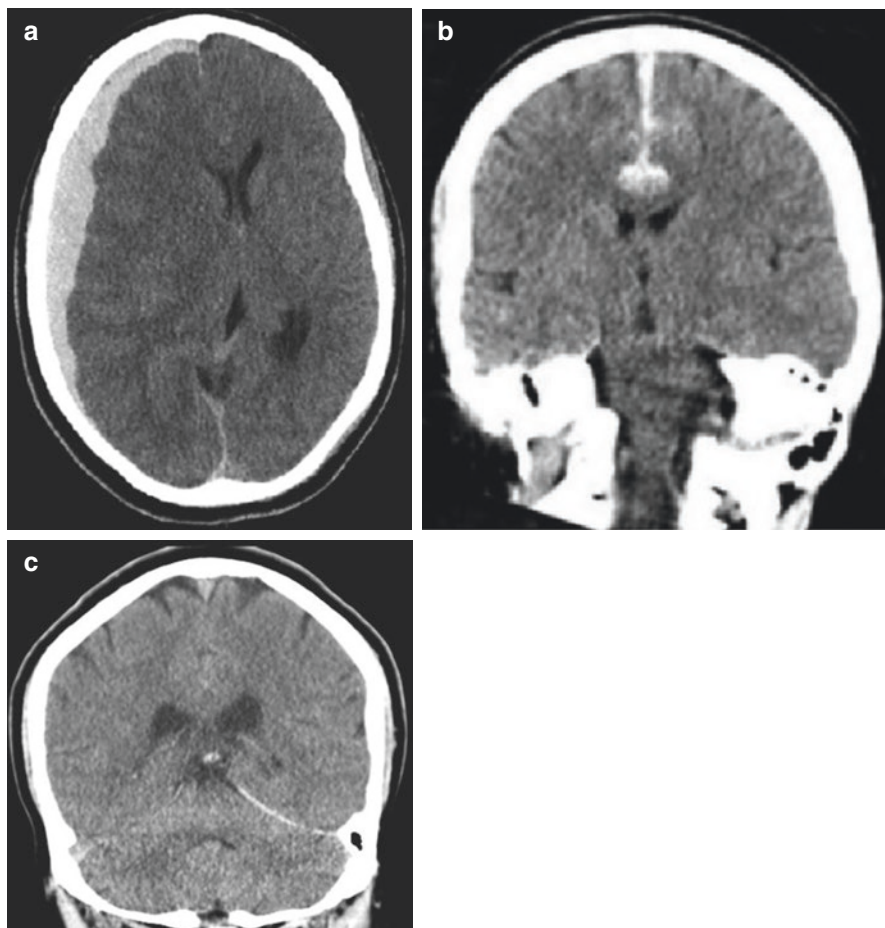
(a) Acute SDH is hyperdense on CT without contrast, is typically crescent-shaped, and can cross suture lines. SDH can be located in any part of the subdural space. (b) Subdural blood along the anterior falx. (c) Subdural blood along the left tentorial leaflet
